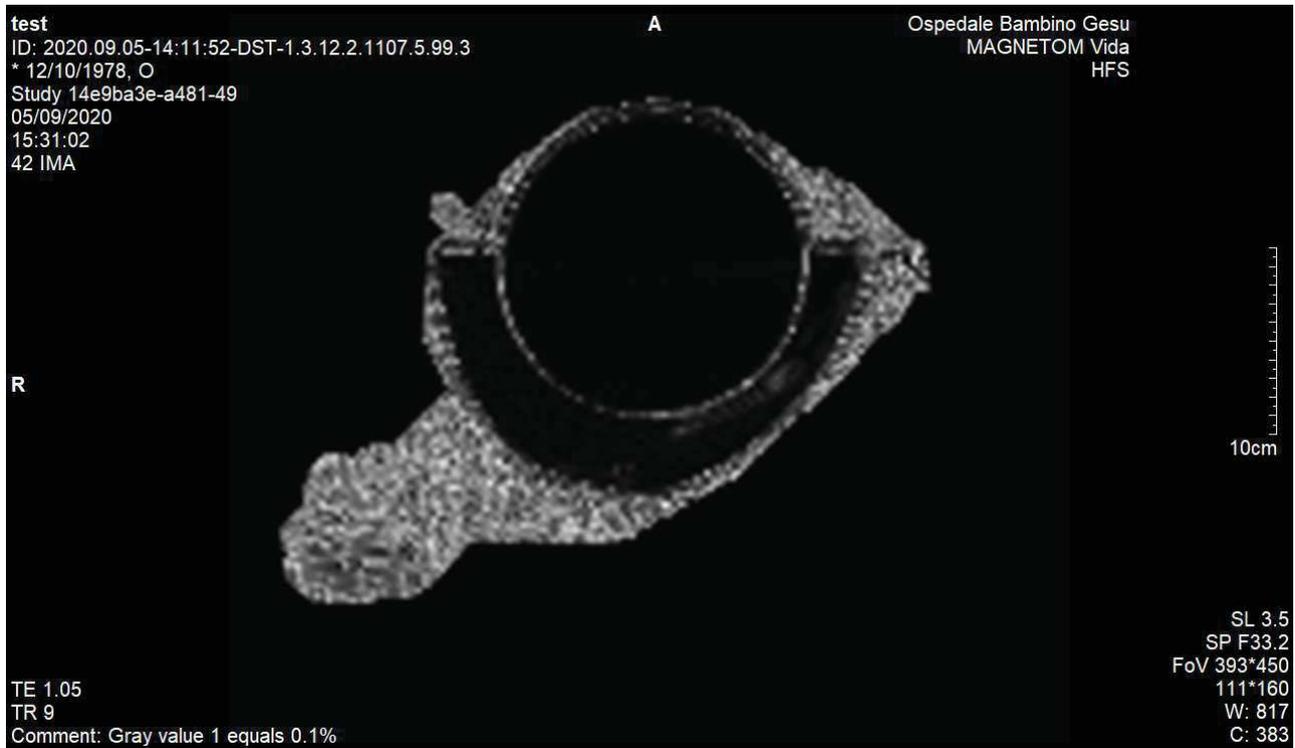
MRI scanned image
